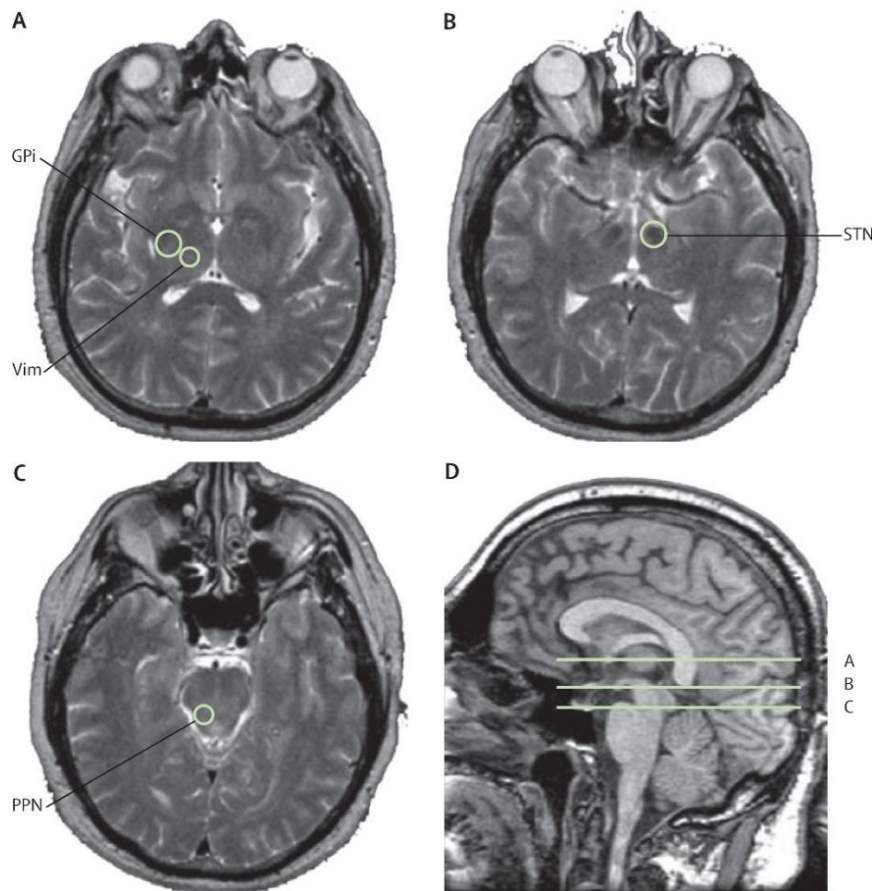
Main target structures of deep brain stimulation, as they appear on T2-weighted brain MRI.
